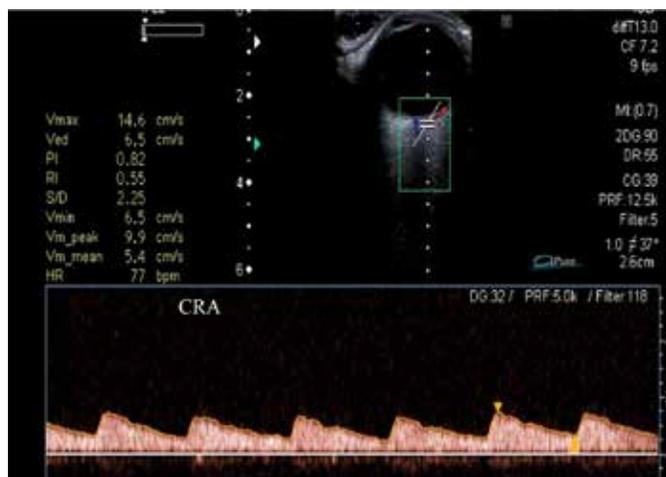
Color doppler image of vessel and corresponding waveform of central retinal artery
